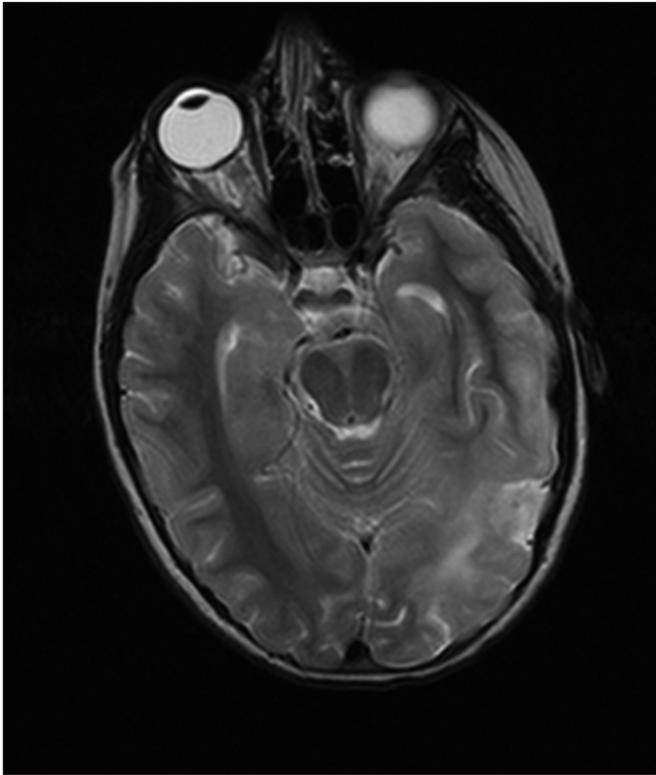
Axial T2-weighted, nonenhanced magnetic resonance image showing left cortical lesion with white matter involvement of the parietal and occipital lobes.
